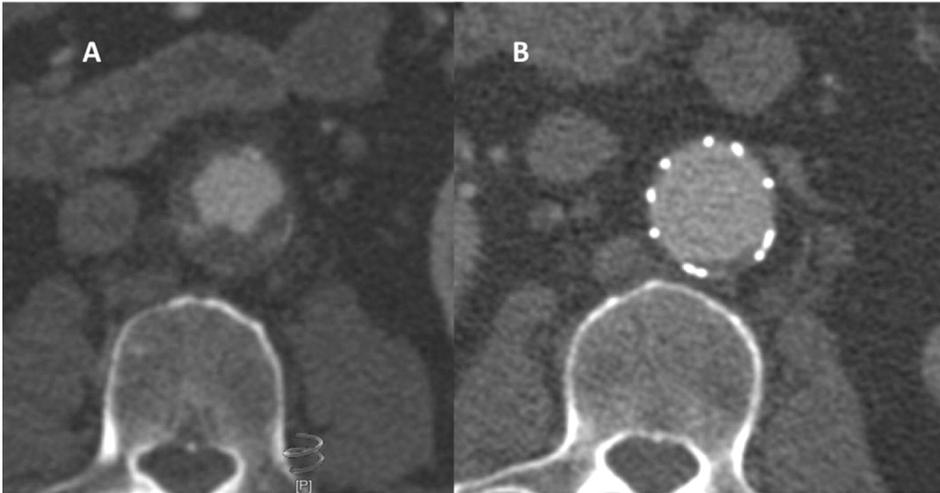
A, A preoperative computed tomography angiography (CTA) shows thick, circular thrombus of the aortic neck. B, At 1 year after endograft implantation, the pre-existing thrombus can no longer be identified. The endograft circumference is in contact with the full diameter of the aortic neck. A thin layer of in-graft thrombus can be identified.
